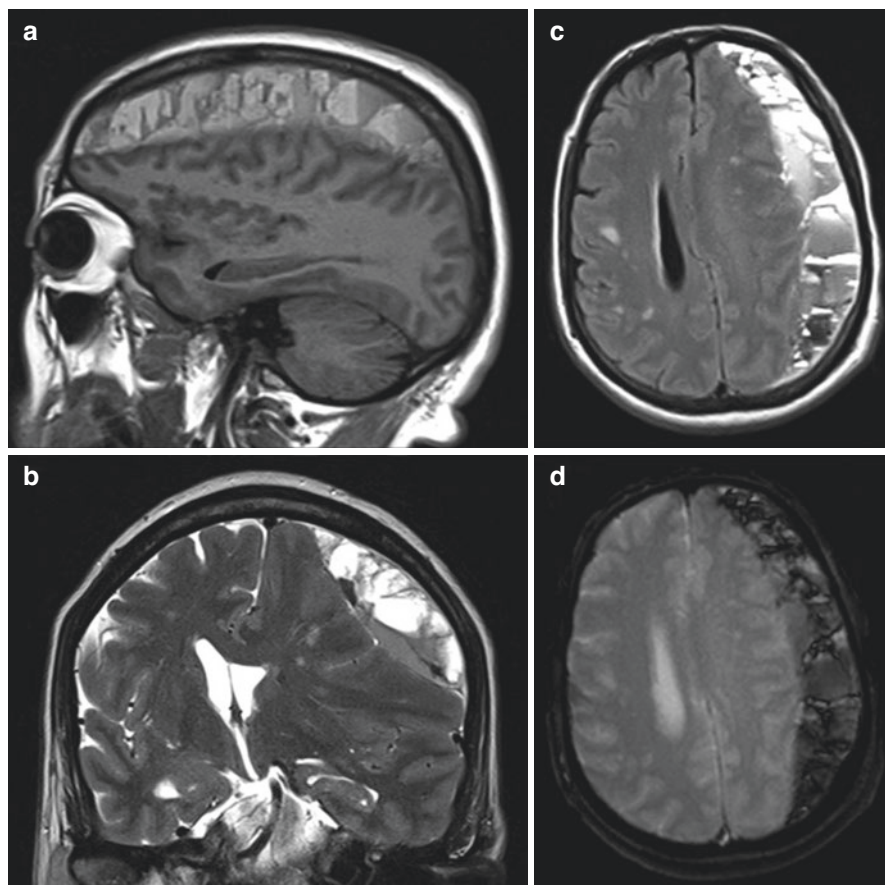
MRI appearance of a heterogeneous mixed intracranial chronic SDH with multilayer loculations on the left side (a–d)
